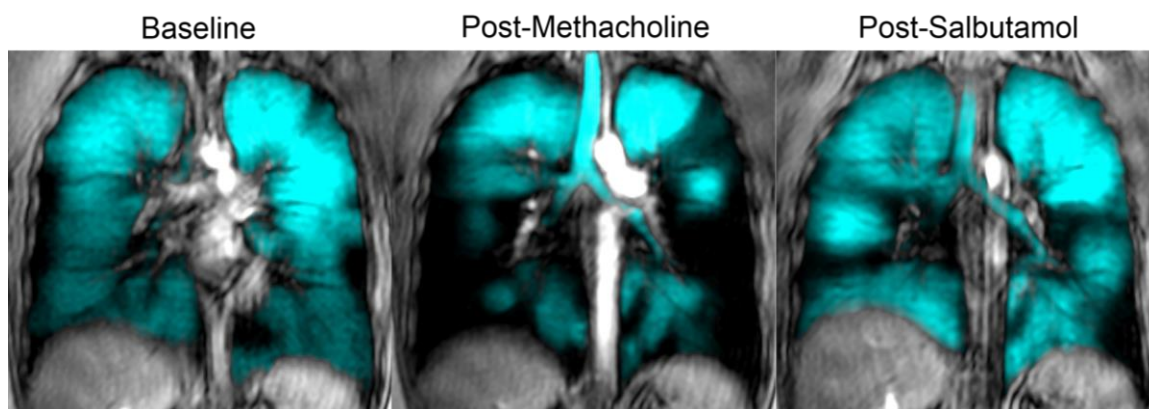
Representative coronal centre slice hyperpolarized ^3He MRI of an asthmatic subject at baseline, post-methacholine and post-salbutamol.
